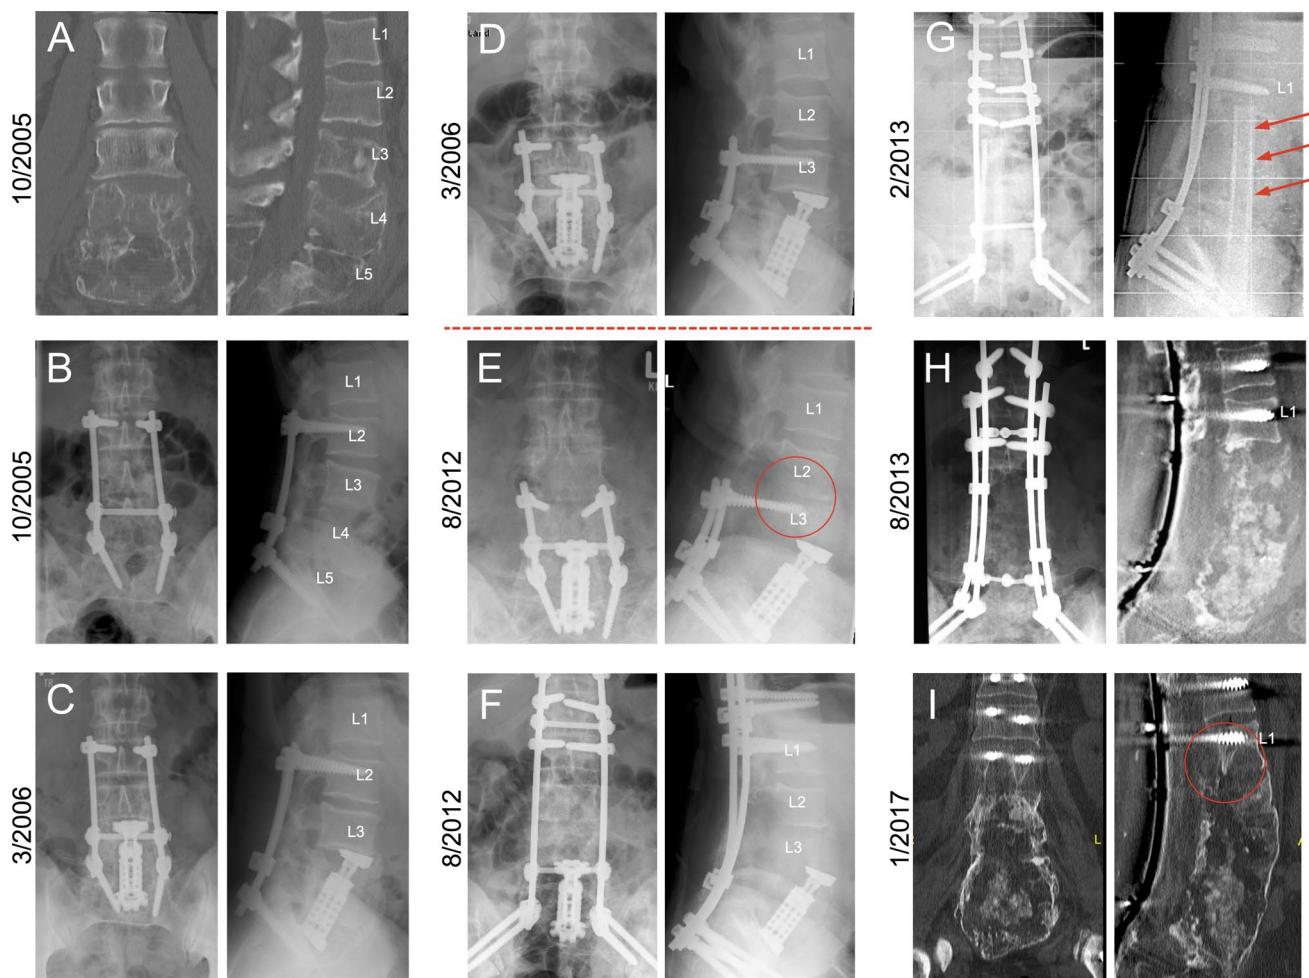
Radiographic progression of spinal PDB in a 46-year-old man. a Coronal and sagittal reformat of the initial CT scan indicate a fragility fracture of L4 and L5. b–i Anteroposterior and lateral radiographies indicate the progression of Paget's disease from 2005 to 2017 (total 12 years follow-up). The surgical interventions that were
